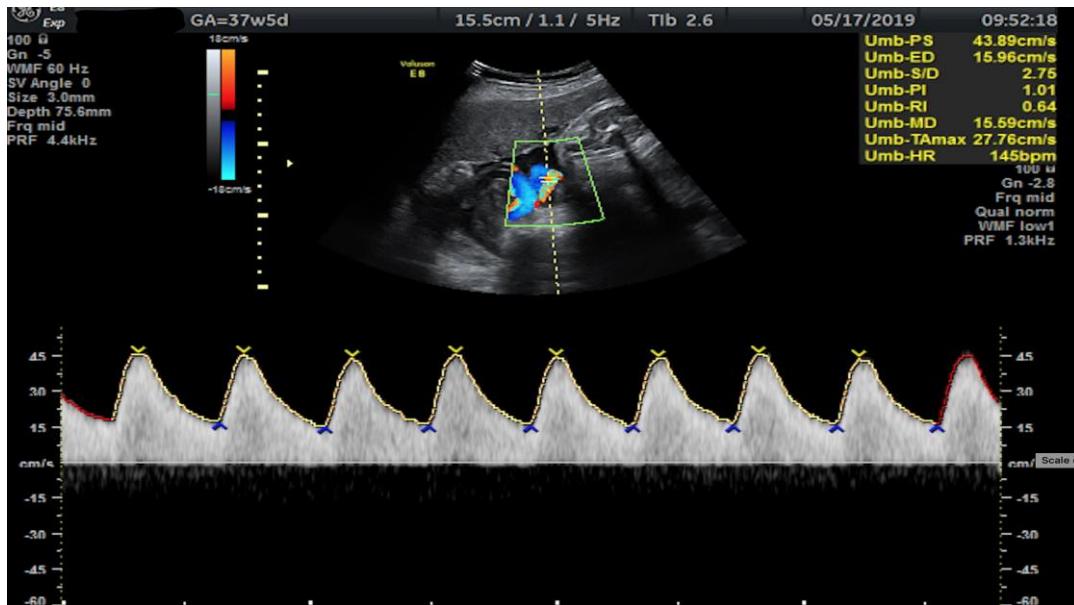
Doppler examination demonstrates the technique of automatic measurement of the blood flow of the umbilical artery. The measurement was taken at 37+5 weeks.
